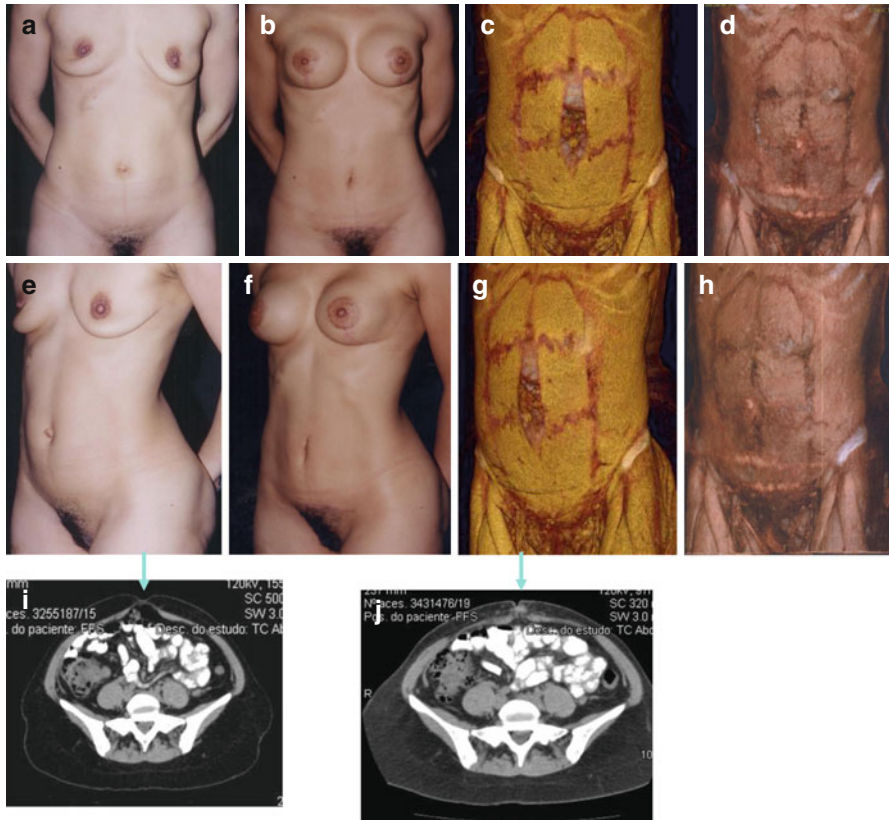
Flaccidity of the abdomen with severe umbilical hernia and diastasis of the rectus abdominis muscle and hypomasty: (a, e) preoperative photos in frontal and lateral views; (b, f) postoperative view showing improvement of body contour with lower abdominoplasty combined with reinforcement of musculo-abdominal wall by sectioning the umbilical pedicle (Callia's technique); (c, g) computed tomography before surgery; (d, h) tomography after operation (i) – tomography before surgery showing umbilical hernia; (j) tomography after abdominoplasty with reinforcement of the muscular flaccidity
